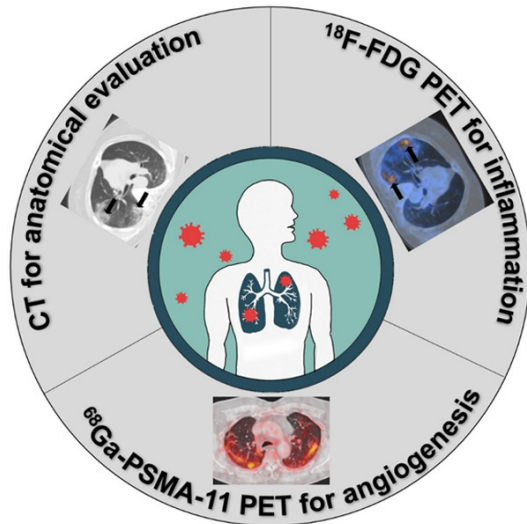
CT, ¹⁸F-FDG PET, and ⁶⁸Ga-PSMA-11 PET imaging of COVID-19. Each imaging modality reveals different aspect of the virus from its infection to progression. CT image and ¹⁸F-FDG PET/CT image adapted with permission from Ref. 11; ⁶⁸Ga-PSMA-11 PET/CT image adapted with permission from Ref. 10.
